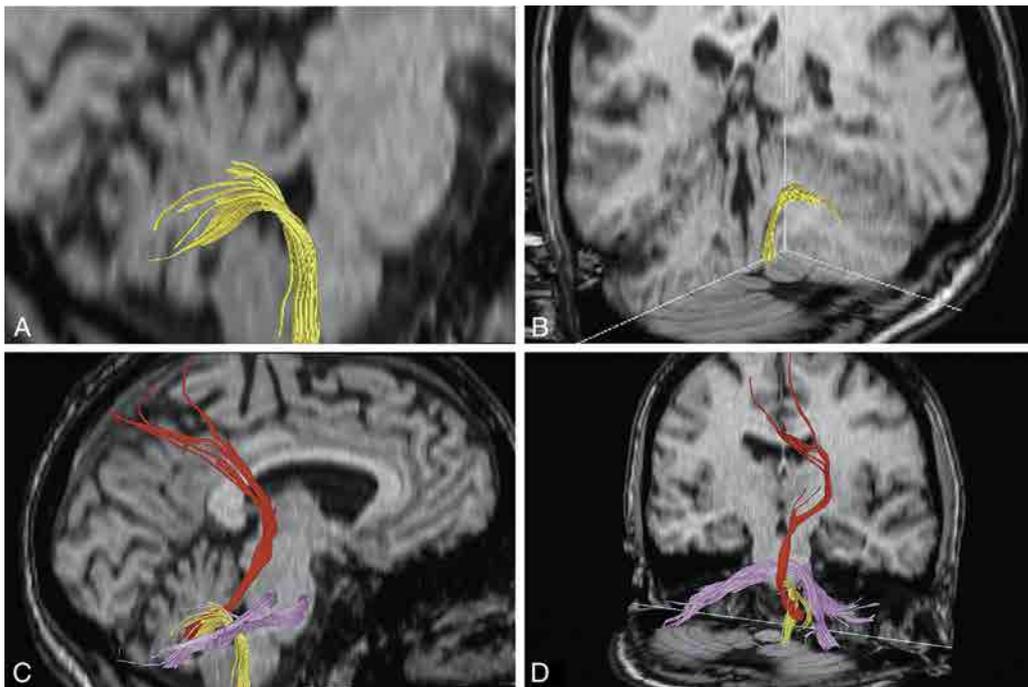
Demonstration of the inferior cerebellar peduncles (A and B) and jointly of the 3 cerebellar peduncles (C and D) through DTT images on different brain MRI planes.
